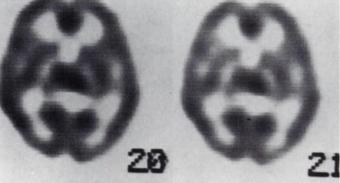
Normal <sup>99</sup>"Tc-HMPAO brain imaging findings in a 50-yr-old woman. Surface three-dimensional display of the brain (upper) and fanbeam SPECT (transaxial slices) of the brain (lower) reveal homogeneous rCBF in the gray matter of basal ganglia/thalamus and cerebral cortex without focal hypoactivity or visible asymmetry.
